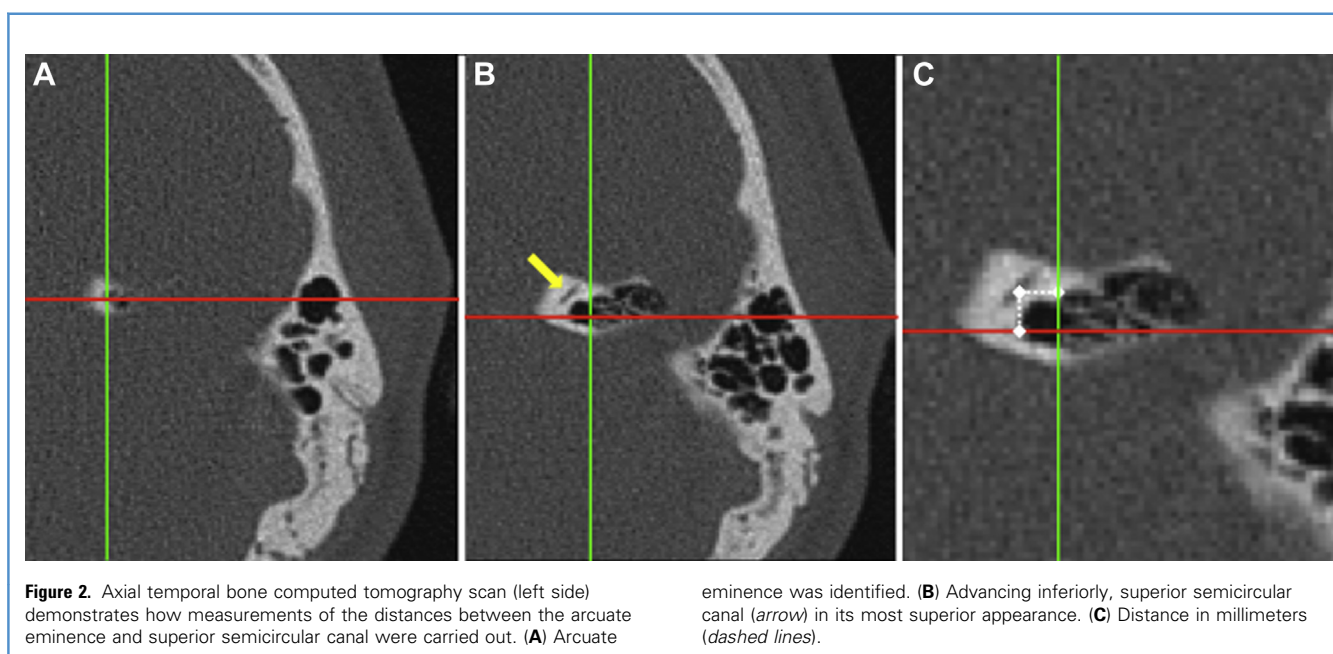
Axial temporal bone computed tomography scan (left side) demonstrates how measurements of the distances between the arcuate eminence and superior semicircular canal were carried out. (A) Arcuate
